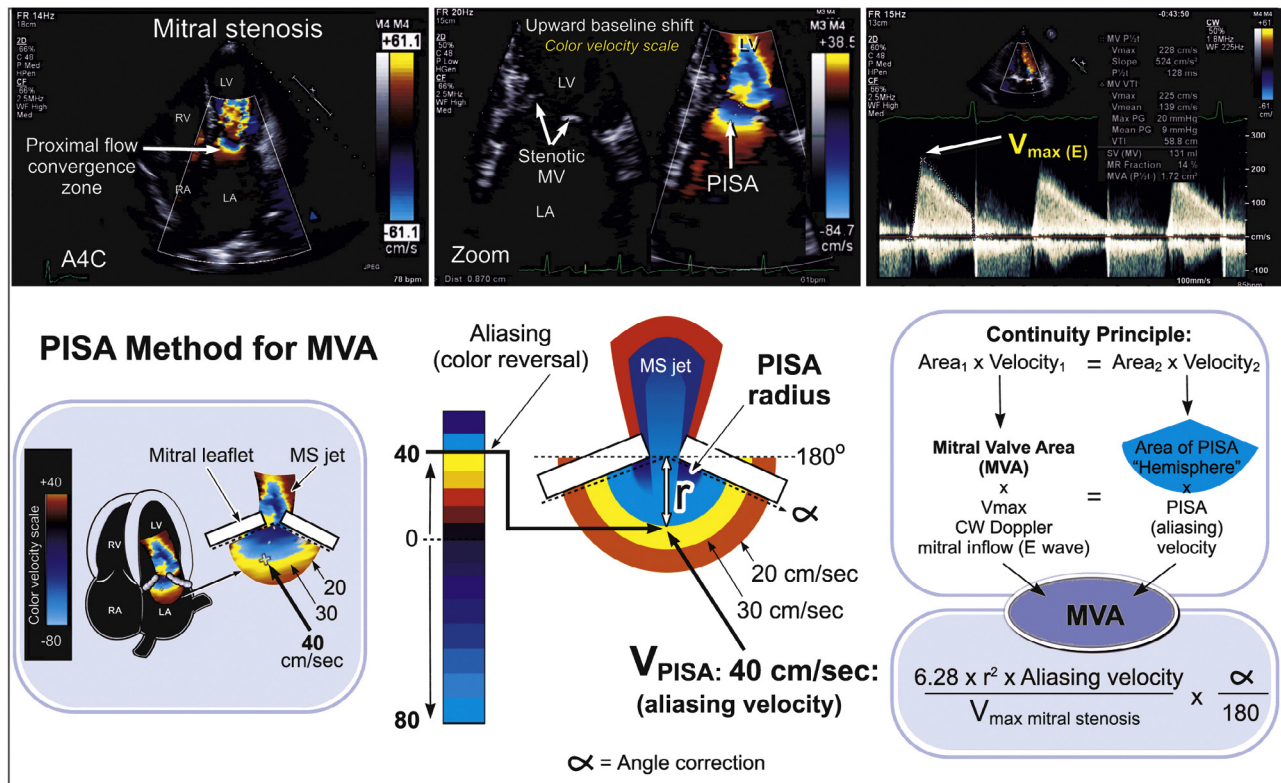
Proximal isovelocity surface area (PISA) method for calculation of MVA. In patients with mitral stenosis (MS), flow acceleration proximal to the stenotic orifice will result in a flow convergence zone that is characterized by color aliasing and a PISA shell (upper left). The definition of the PISA shell and thus accuracy of the PISA radius measurement can be improved by shifting the baseline Nyquist limit in the direction of flow (upper middle). In the lower left and middle panels, the aliasing velocity is 40 cm/sec. Application of the continuity equation allows MVA to be calculated as $MVA = [2(\pi r^2)(V_{aliasing})(Peak V_{mitral})] \times \alpha/180$. The angle correction is used to correct for deviation of the shell from hemisphericity. A4C, Apical four-chamber view.
